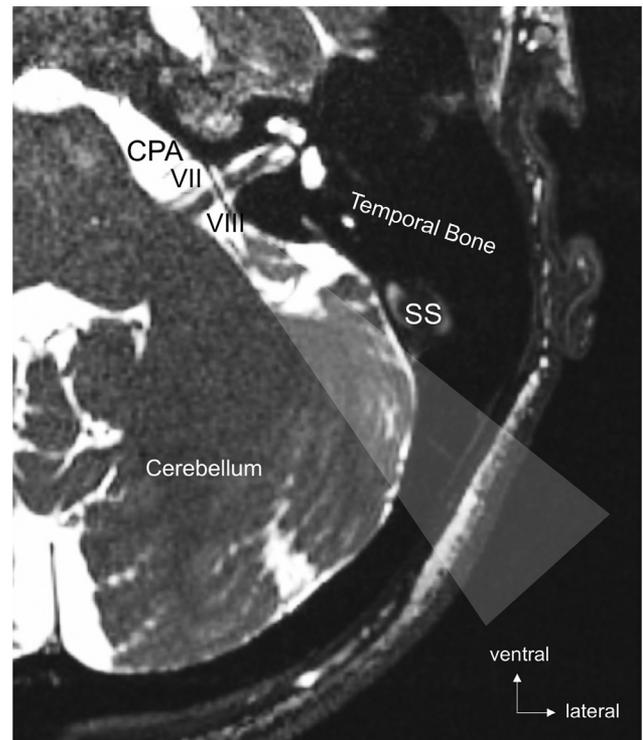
Magnetic resonance image axial section. The highlighted cone represents the line of sight of the surgeon in the retrosigmoid approach that allows access to the cranial nerves VII and VIII in the cerebellopontine angle (CPA). In some cases, the cerebellum has to be cautiously retracted. SS, sigmoid sinus.
